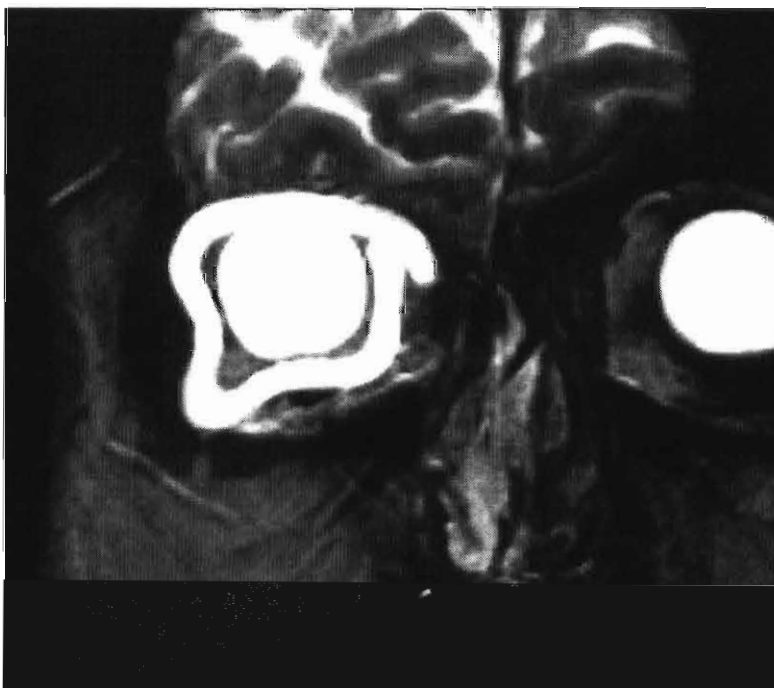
Coronal magnetic resonance image demonstrating Miragel element enlargement as the cause of the inferotemporal bulge.
